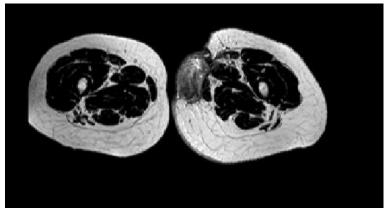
a) MRI showing hypointense mass 75 mm in the craniocaudal direction with skin infiltration and involvement of the left adductor lungus muscle b) PET showing left femoral uptake (SUVmax 10.7)
